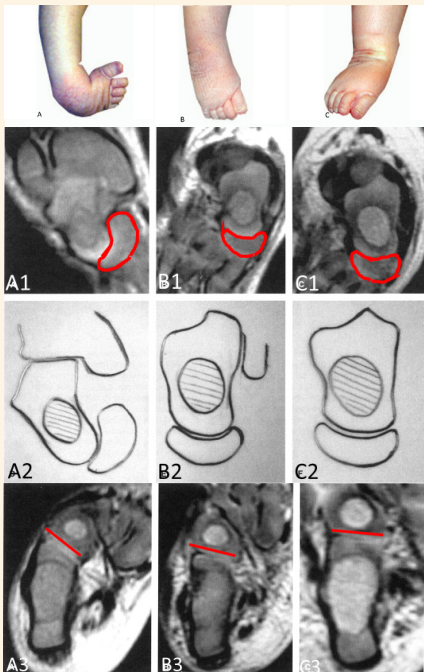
Temporally matched clinical photos of a clubfoot and MRI images from Pirani's study before (A, A1, A2, A3), during (B, B1, B2, B3), and at the end of Ponseti cast treatment (C, C1, C2, C3). Note the changes in the talonavicular joint and calcaneocuboid joint. Before treatment, the navicular (red outline in A1) is displaced to the medial side of the head of the talus. [The following was written by Dr. Mosca] Note how this relationship normalizes during cast treatment as the navicular and the rest of the subtalar joint rotate laterally around the talar head (A1, B1, C1 and A2, B2, C2). The calcaneocuboid joint (red line) is in varus alignment initially (A3). The calcaneocuboid joint is a stable joint, unlike the mobile talonavicular joint. The change in alignment at the calcaneocuboid joint is due to remodeling of the adjacent cartilaginous anlagen. The varus orientation of the calcaneocuboid joint changes to neutral (perpendicular to the calcaneus) according to the Heuter-Volkman property of growing cartilage (A3, B3, C3). Finally, note the remarkable similarities between images A, A1, A2, and A3 with Dr. Ponseti's stillborn dissection in Figure 4. [From: Pirani S, Zelnik L, Hodges D. Magnetic resonance imaging study of the congenital clubfoot treated with the Ponseti method. *J Pediatr Orthop*. 2001;21:719-726, Figures 5 and 8]
